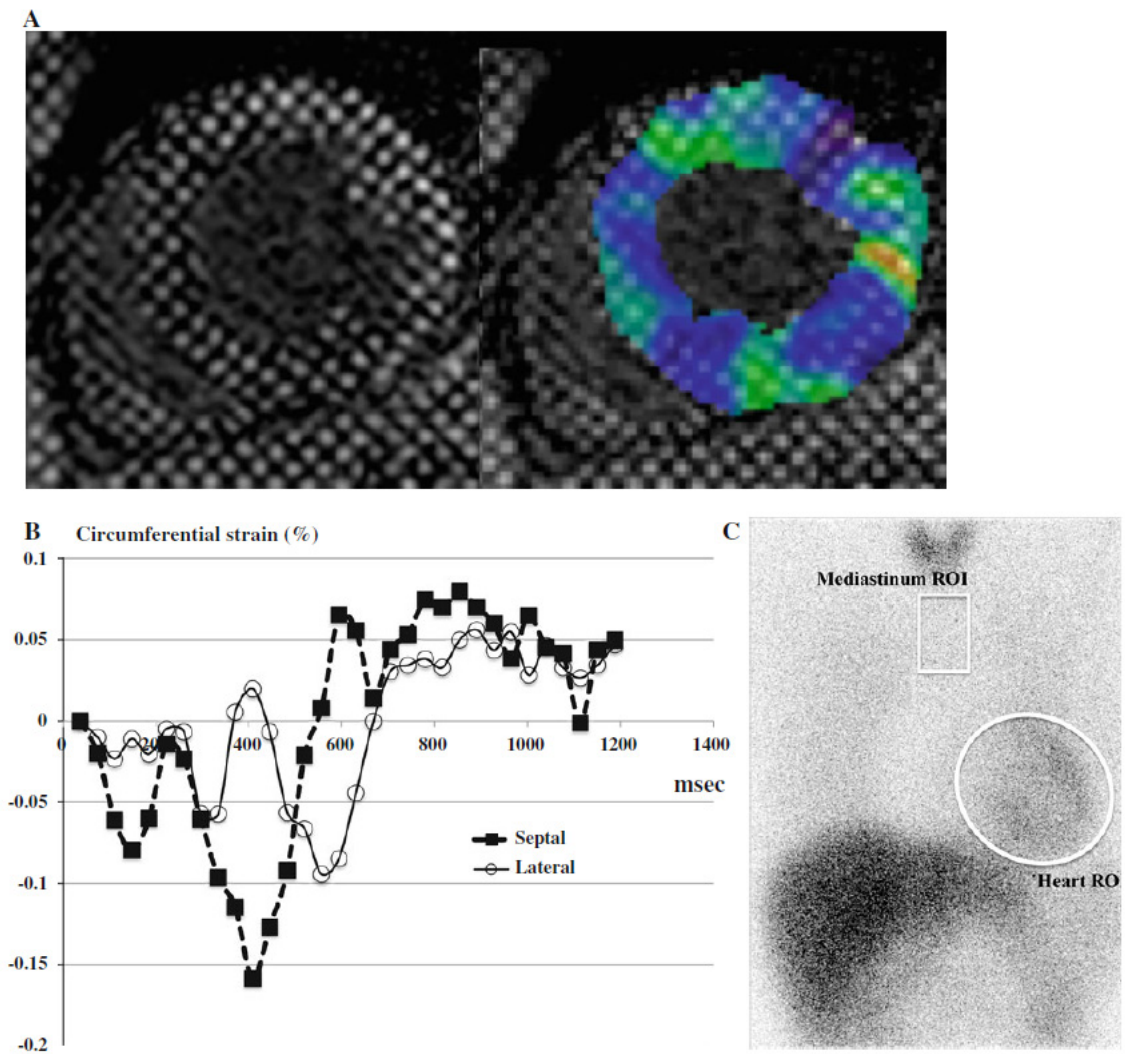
An 18-year-old man with DCM. A Short-axis mid-ventricular views of cine-tagging MR images at end-systole (left). The inTag Osirix software for tag analysis automatically plotted the area of the left ventricle and produced a color-coded strain map that shows low values as cold colors and high value as hot colors (right). B Circumferential strain time curves for mid-septal and midlateral segments. The x-axis indicates time (milliseconds) and the y-axis indicates the circumferential value. The
